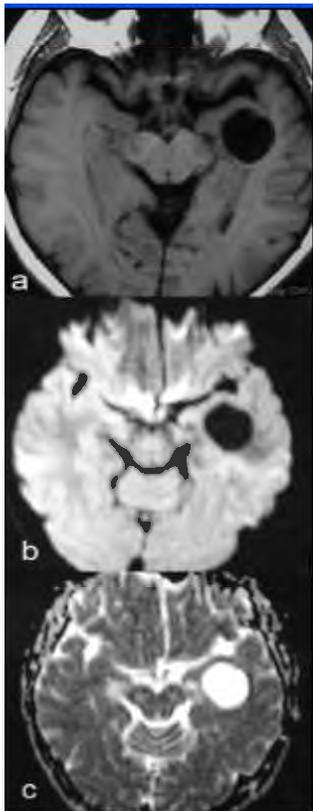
Another dilated PVS located at the left subinsular region. T1W axial image (a), There is no diffusion restriction at the DWI (b=1000) image (b) or no restriction findings at the relevant ADC map image (c).
